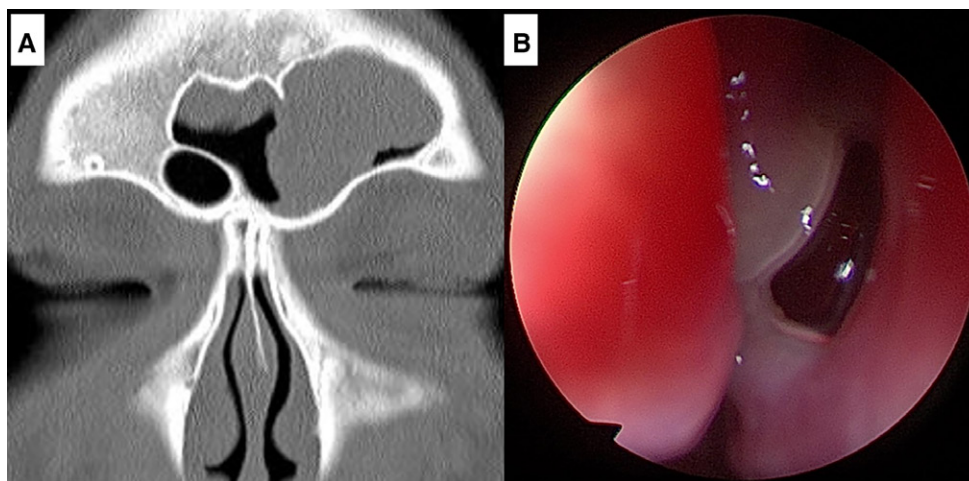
Initial head CT and nasal endoscopy images of an acute left frontal sinus barotrauma/barosinusitis/aerosinusitis. A) Initial head CT image showing an opacification in the left frontal sinus. B) Nasal endoscopy image of the left middle meatus showing a severe mucosal swelling with serosanguinous discharge drained from the left frontal sinus.
